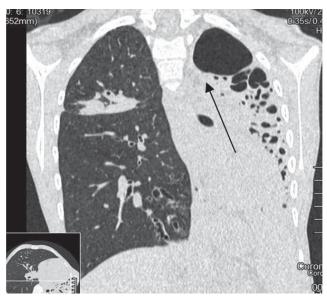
Pulmonar CT – Left pulmonary fibroatelectasis, reduced left hemithorax, mediastinum moving to left, 3x3.4cm air bubble in the upper left lobe. 8-year-old child, with FC, chronic pulmonary infection with 2 multiresistent strains of Ps. aeruginosa, CFTR genotype delF508/X
